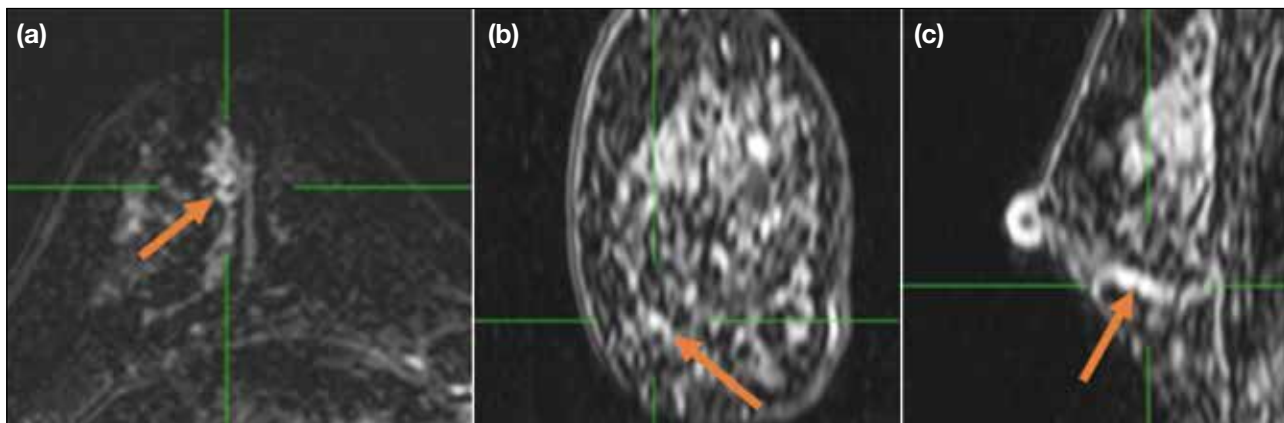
A 52-year-old woman with left breast carcinoma. Incidental note of linear non-mass enhancement (NME) in the right inferior breast on magnetic resonance imaging (arrows); biopsy on second-look ultrasound revealed usual ductal hyperplasia and intraductal papilloma and patient subsequently had left breast-conserving therapy. Reformatted axial (a), coronal (b) and sagittal (c) post-contrast T1-weighted images with subtraction show linear NME in the right inferior breast.
